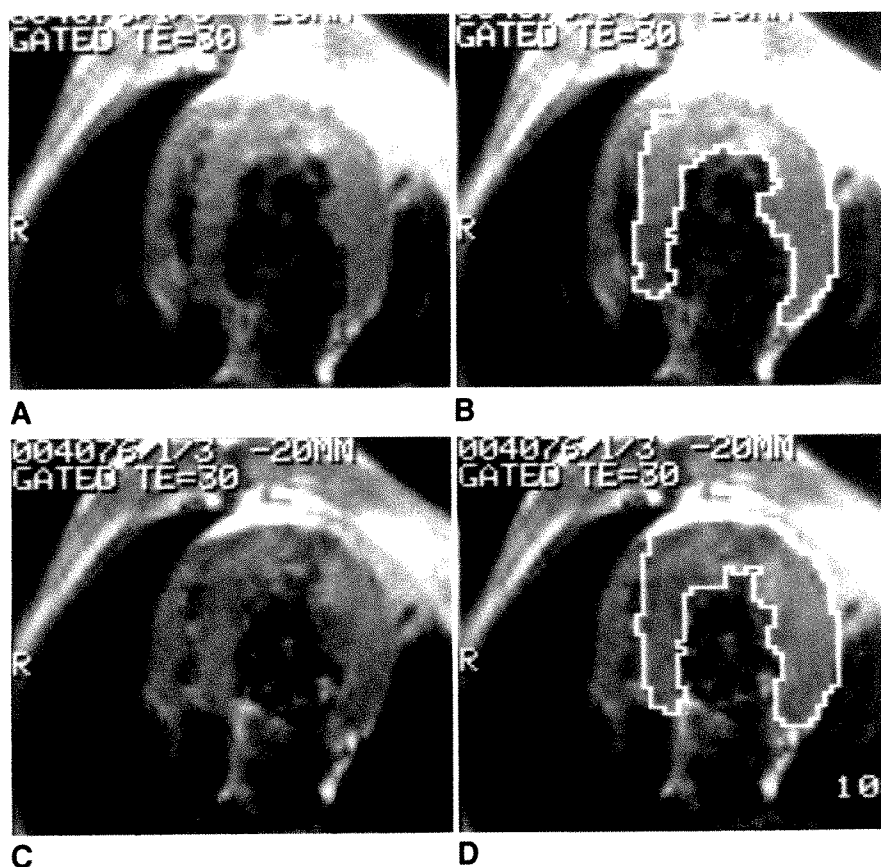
Transaxial midventricular MR images.
